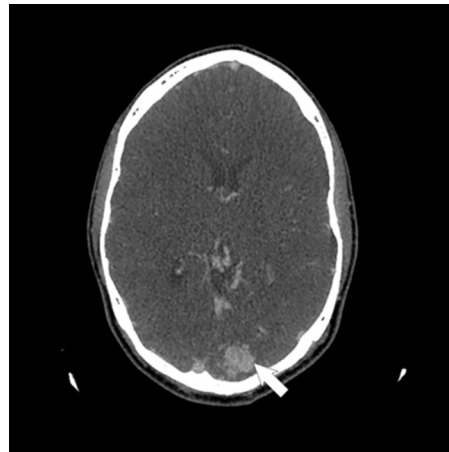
Computed tomography angiography imaging from second presentation (age 31) demonstrating a left occipital hyperdensity (white arrow) suggestive of a left occipital arteriovenous malformation with no evidence of intracranial hemorrhage.
